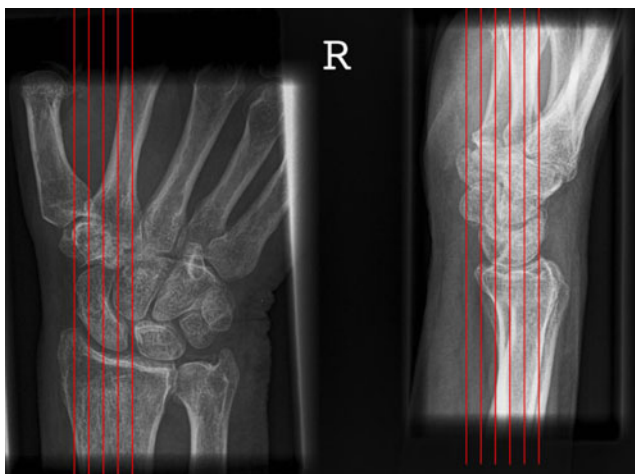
Planes of the wrist on PA and lateral radiographs, respectively. The *red lines* represent the plane of the wrist in which the scans are reformatted
